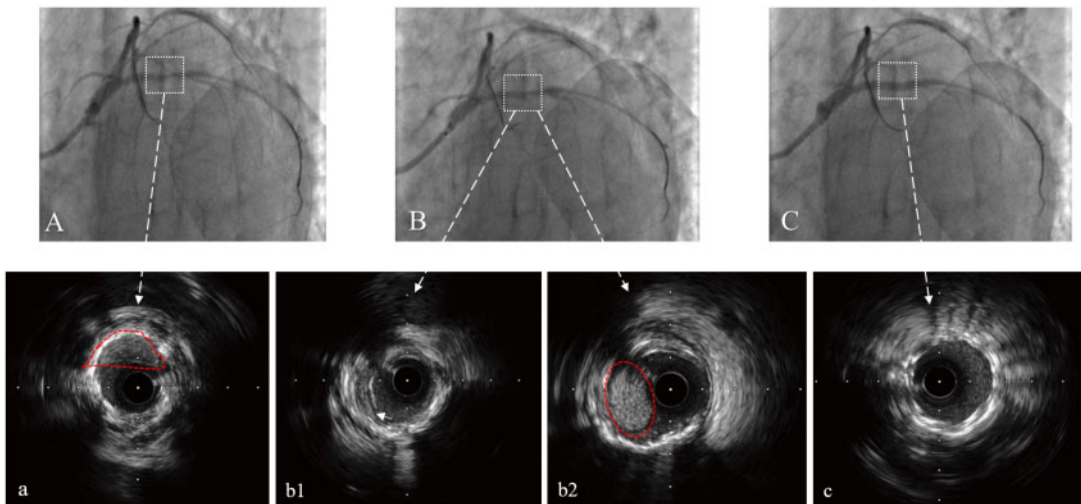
(A) Coronary angiography and the corresponding intravascular ultrasound revealed intrastent haematoma (red dashed area in figure a). (B) Haematoma was not relieved after dilatation with a cutting balloon (intimal flap was shown in figure b1, white arrowhead; the following intrastent haematoma was marked with a dotted red line in figure b2). (C) Final results confirmed complete sealing of the haematoma after drug-eluting stent implantation.
